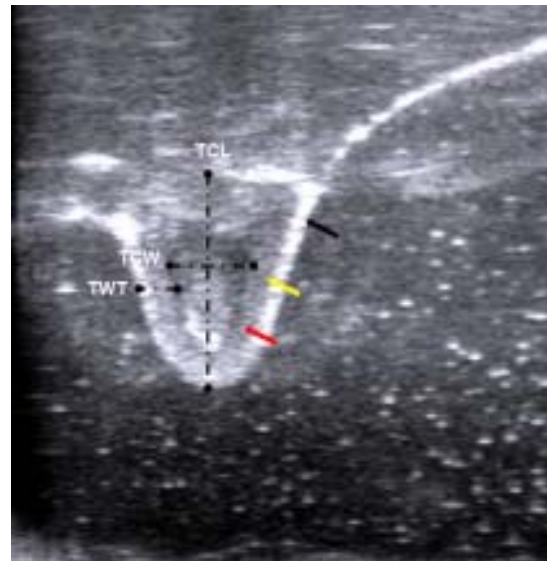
Sagittal ultrasound scan of the teat in lactating Jenny demonstrating the multi-layered structure of the teat including outer thin hyperechoic skin (black arrow), thick, hypoechoic muscle layer (yellow arrow) and thin hyperechoic mucosa (red arrow). The teat canal length (TCL), teat canal width (TCW) and teat wall thickness (TWT) are also presented.
